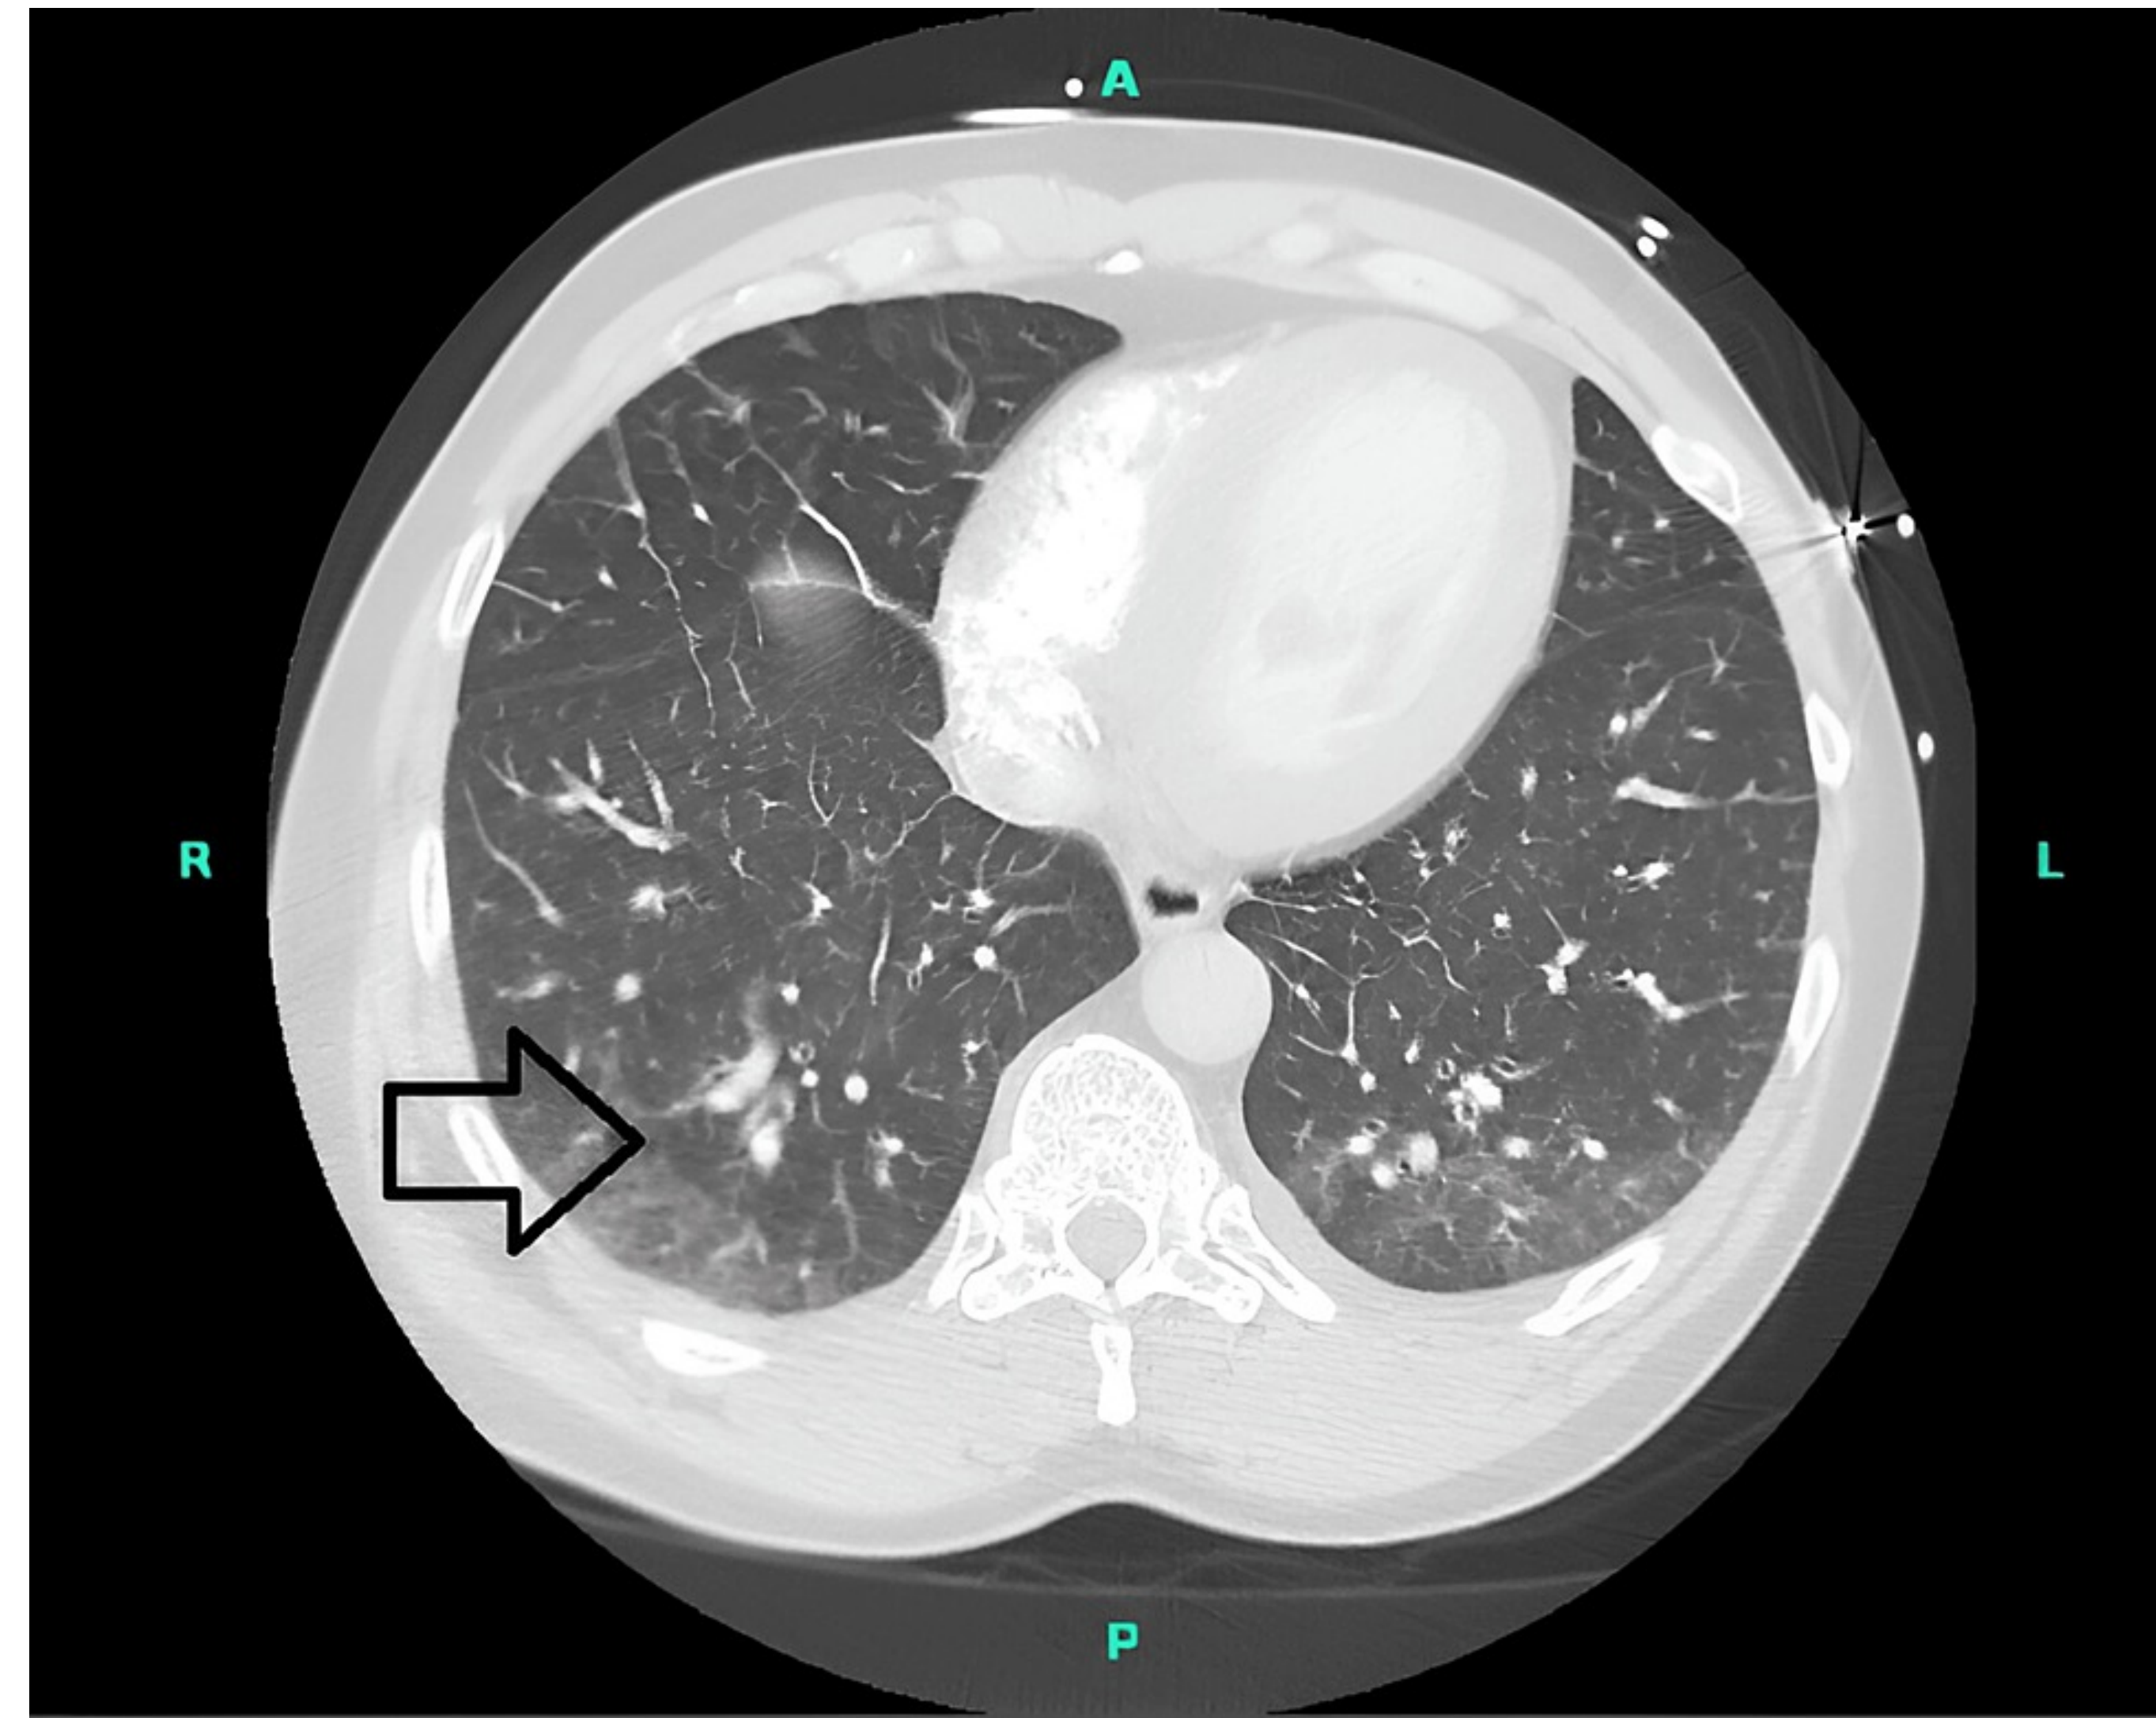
CT chest on admission showed right sided alveolar opacities (arrow), suggesting possible edema/ pneumonia and emphysema. Left lung showed similar consolidation but to a lesser degree.<sup>2</sup>
